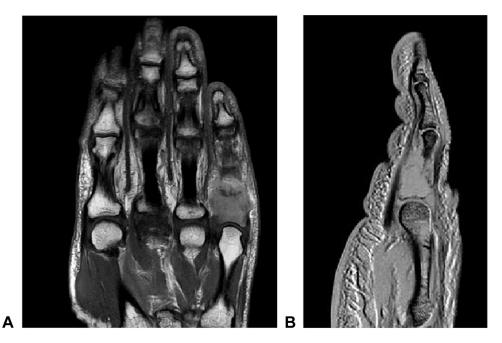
A Magnetic resonance imaging reveals the existence of an intraosseous infiltrating mass. B Magnetic resonance imaging reveals the existence of an intraosseous infiltrating mass.
